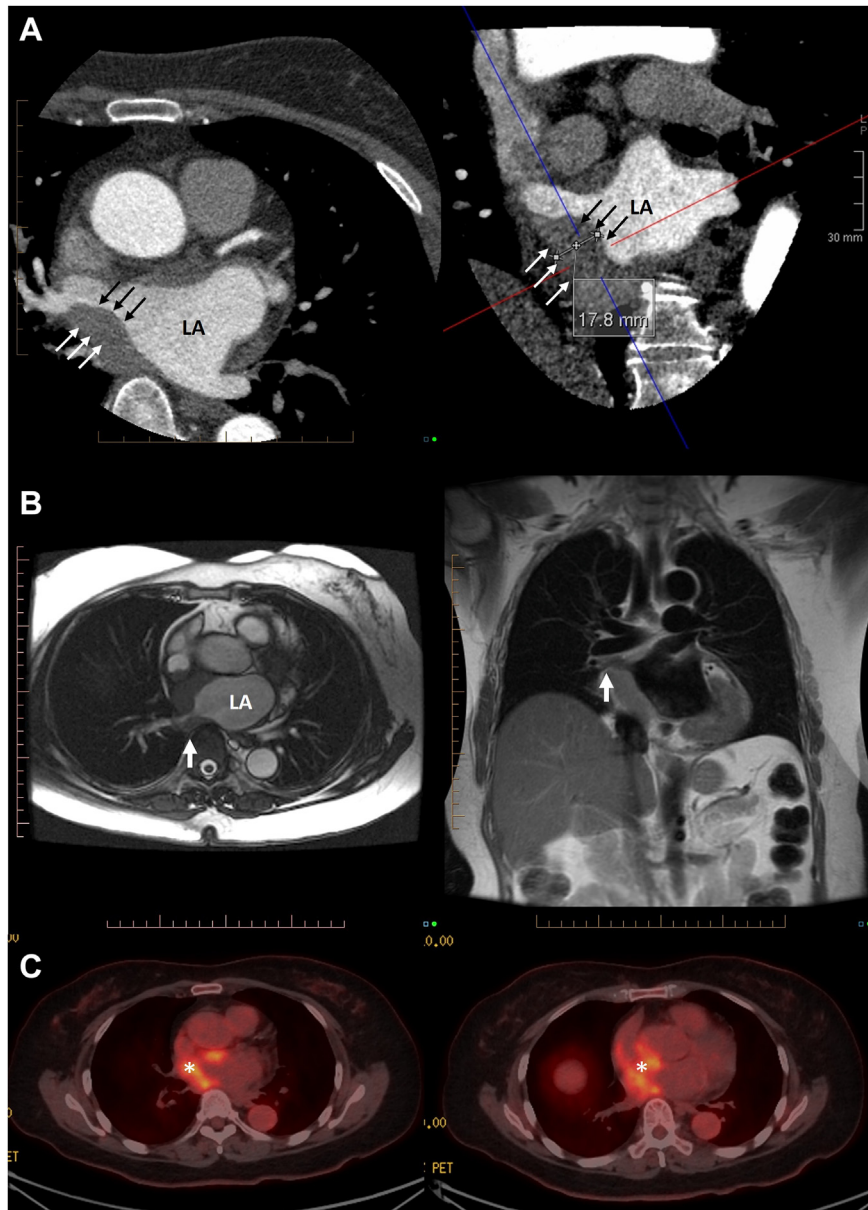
Multimodality imaging for evaluation of precise anatomic mass location and metabolic activity. (A) Cardiac CT, axial (*left*) and multiplanar oblique coronal (*right*) displays, demonstrates a poorly demarcated focal thickening of the posterior LA (*arrows*), between the right superior and inferior PVs and interatrial septum, measuring up to 18 mm, resulting in mild narrowing of the right superior and moderate stenosis of the right inferior PVs. (B) Cardiovascular magnetic resonance scan, balanced steady-state free precession axial display (*left*) and black-blood spin-echo sequence coronal display (*right*), demonstrates a soft tissue mass (isointense relative to the myocardium) encasing and stenosing the right-sided PVs (*arrows*) with encroachment on the superior vena cava. (C) Positron emission tomography with 198.6 MBq of FDG, superior (*left*) and midventricular (*right*) axial displays, demonstrates that the asymmetric left atrial wall thickening was intensely FDG avid (*).
